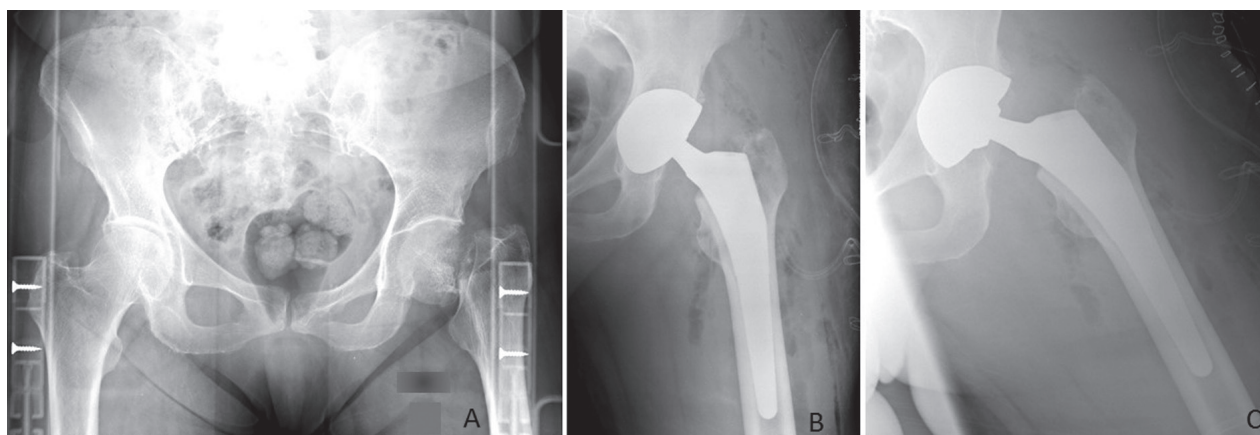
A 73 years old woman reported a left displaced FNF treated with a DM THA the day after trauma. A) pre-op radiograph showing left FNF B) AP and C) axial post-op radiographs of the prosthetic implant
